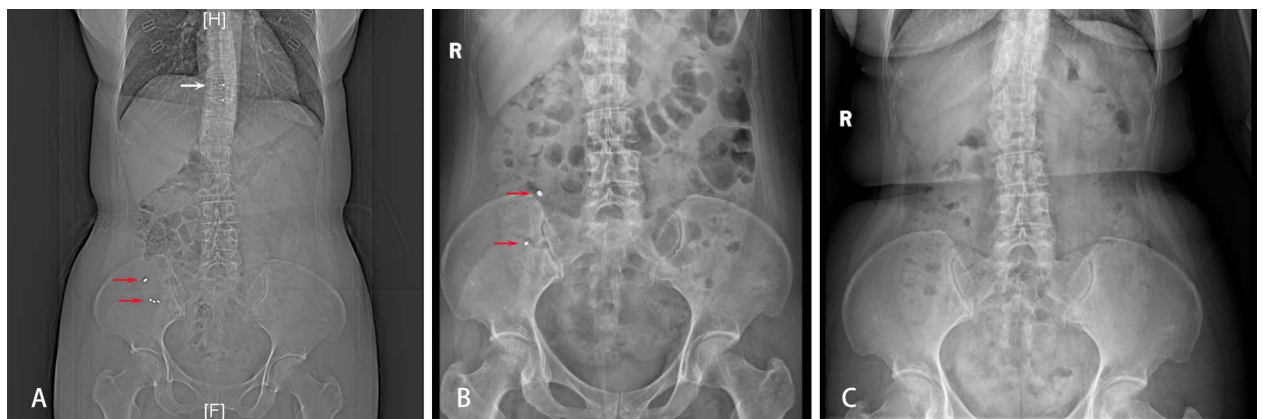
The movement of four high-density objects in the patient’s abdominal X-rays, captured preoperatively (A), immediately after the surgery (B), and one-week postoperative follow-up (C) respectively.
